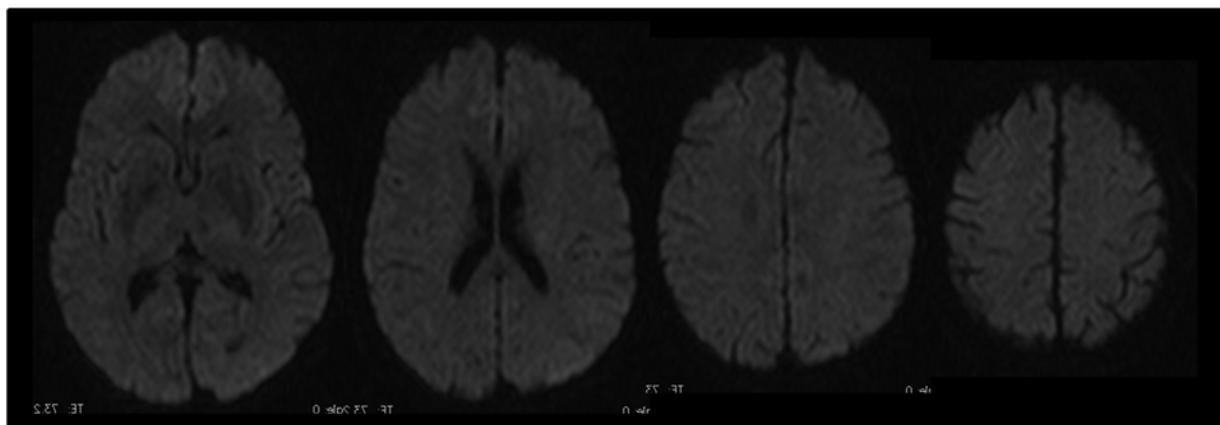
Brain magnetic resonance imaging performed after onset of symptoms
